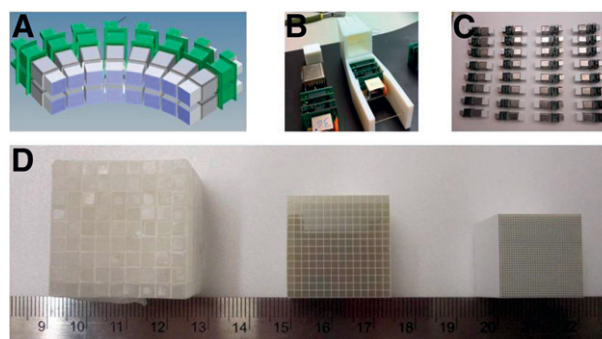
A) Detector head design layout for non-DOI prototype breast scanner. B) Detector components and gantry support modules for non-DOI scanner. C) Detector components (arrays, pmts, pre-amp stacks) awaiting gantry mounting. D) Left: LSO array for the existing breast PET/CT (3.3 mm pitch). Center: 1.5 mm pitch LSO array. Right: 0.5 mm pitch ultra high-resolution array.
